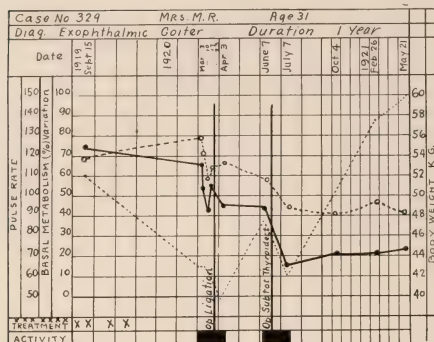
Figure I—Case No. 329. Exophthalmic goiter. Graphic chart showing change occurring in the basal metabolic rate and pulse. X-ray treatment indicated at the bottom by a cross.
